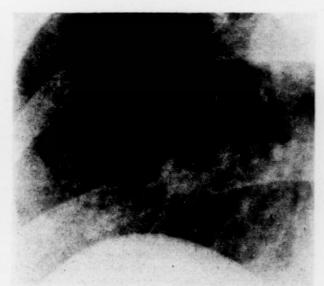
Enlarged view of the right lower lung field of the chest x-ray taken on the thirtieth day of illness. There is a reticular pattern resulting from the diffuse increase in interstitial markings.
